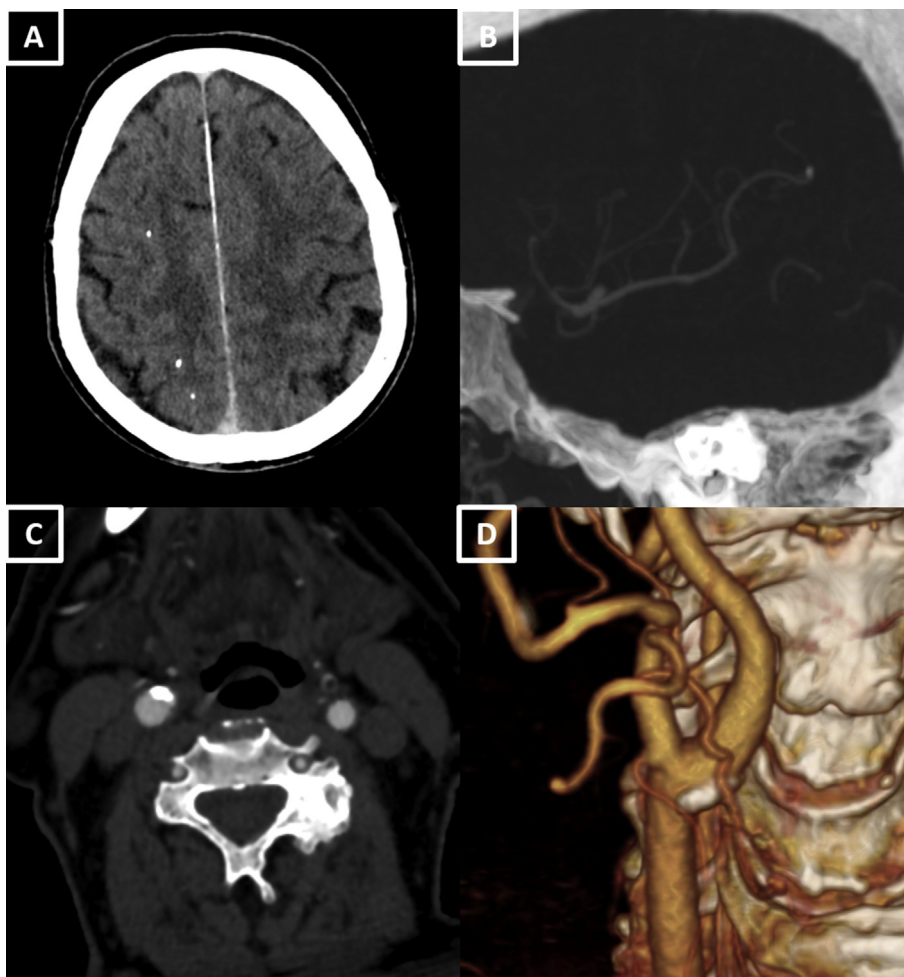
(A) Axial contrast enhanced cerebral computed tomography cerebral angiogram (CTA) showing multiple calcified cerebral emboli in the right middle cerebral artery (B) Calcified embolus in the M3 segment of the right middle cerebral artery seen in multiplanar reconstruction (C) Axial cervical CTA showing a calcified right carotid plaque without significant stenosis (D) Three dimensional CTA reconstruction of the right carotid bifurcation.
